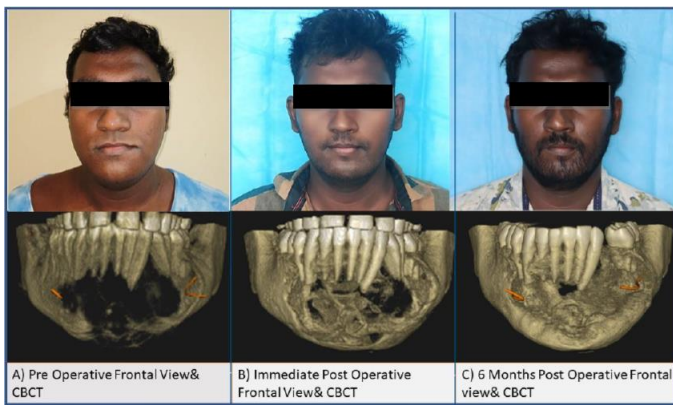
Preoperative Frontal view & CBCT, 1B- Immediate Postoperative Frontal view & CBCT, 1C-6 months Post-operative Frontal view & CBCT
